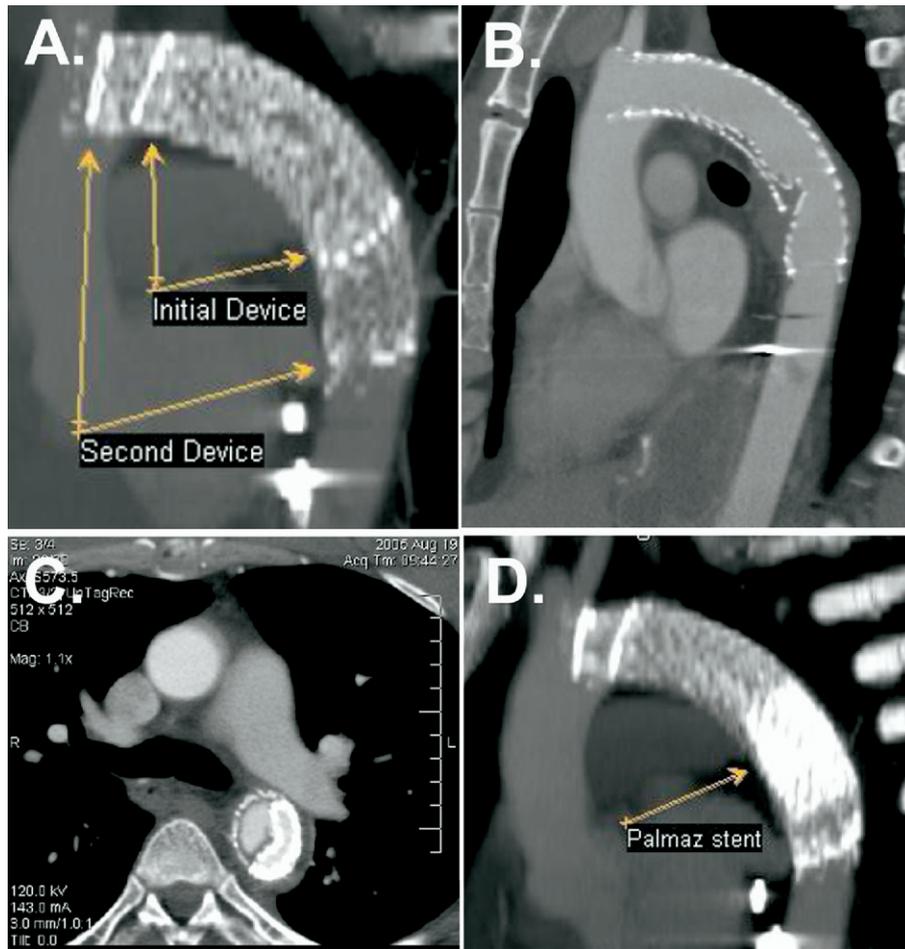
In one patient, attempts were made to correct the graft infolding through endovascular salvage with the implantation of additional endoprosthesis inside a collapsed TAG. This attempt was unsuccessful. A, A TAG (28 mm × 10 cm) was deployed first, but owing to a proximal type I endoleak, a second TAG (28 mm × 15 cm) was deployed slightly more proximally. B and C, Computed tomography (CT) imaging showed clear infolding of the second TAG. D, To treat the infolding, a giant Palmaz stent was deployed. A CT scan 1 day after the placement of the Palmaz stent showed complete infolding of both the second TAG as well as the Palmaz stent.
